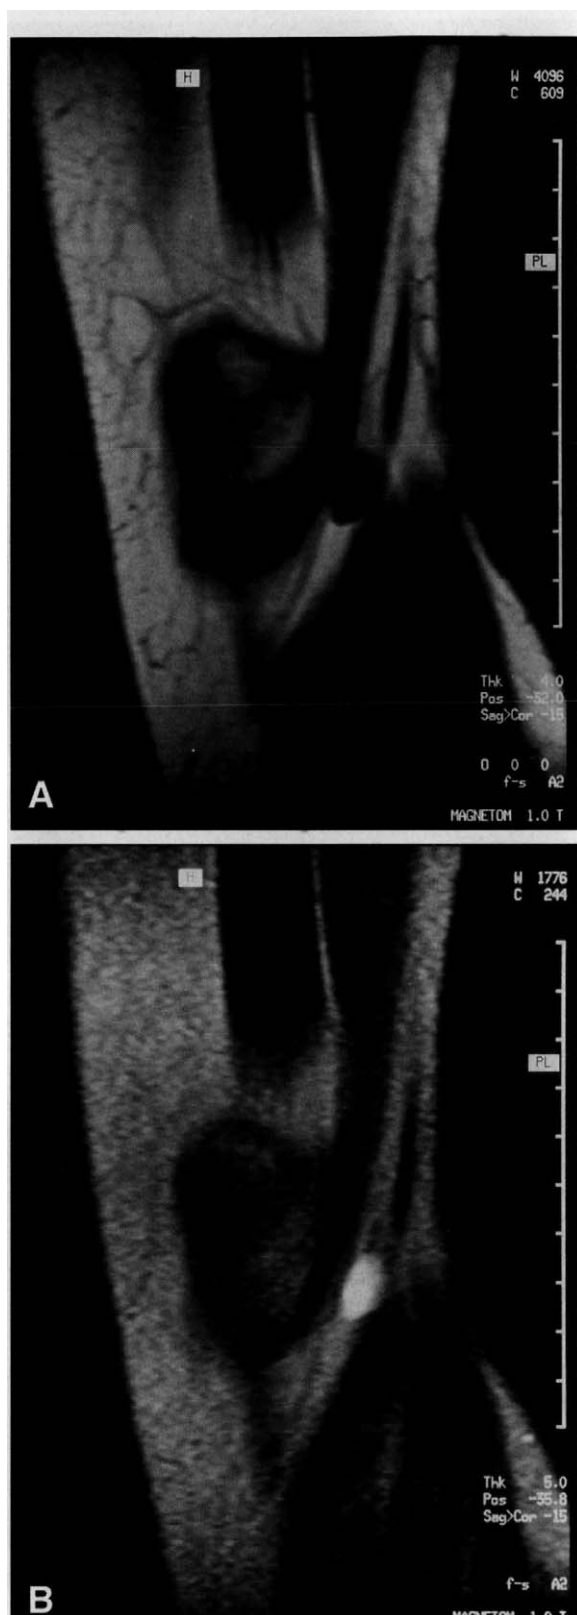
Ganglion cyst in an asymptomatic 30-year-old woman. A, sagittal T1-weighted spin echo sequence revealing low signal intensity of cyst. B, sagittal T2-weighted spin echo sequence demonstrating high signal intensity of cyst.
